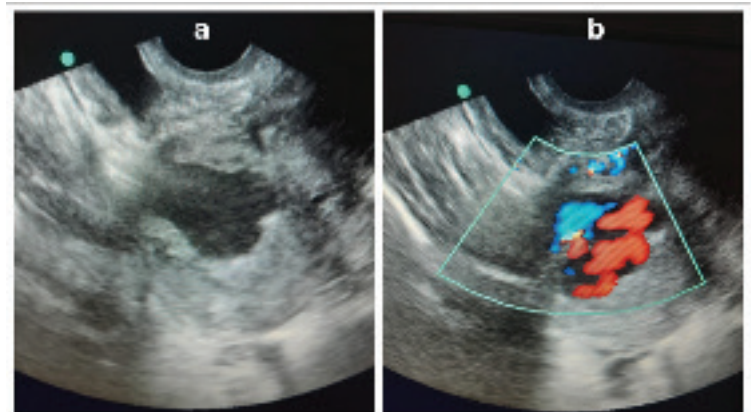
Transvaginal sonography. (a) This showed thin endometrium and cystic lesion in the uterine fundus invading the anterior myometrium. Color Doppler (b) showed hyper-vascularity, suggestive of A-V malformation
